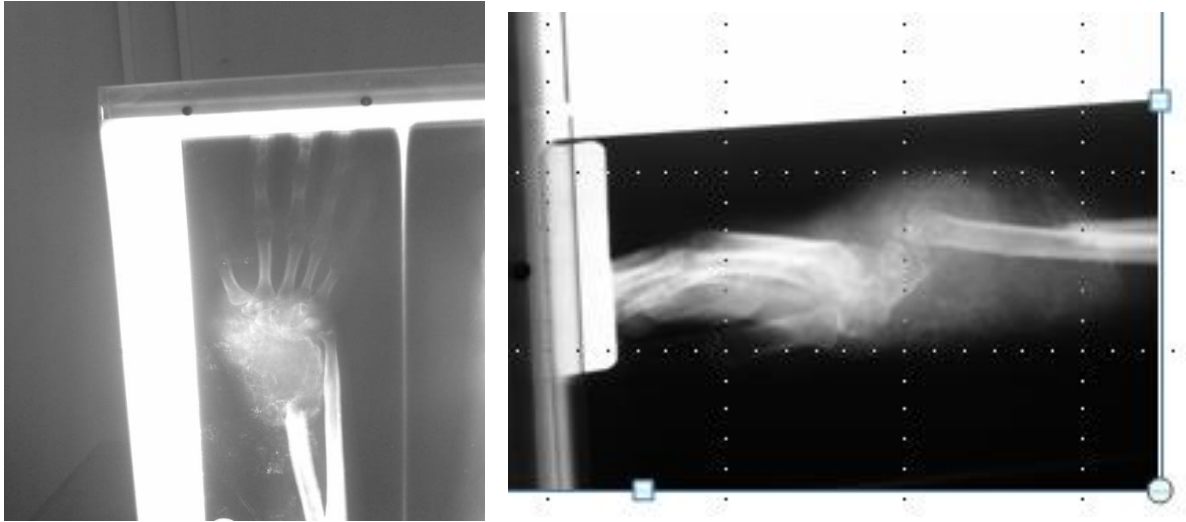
and Figure 2. Pre operative Xrays
